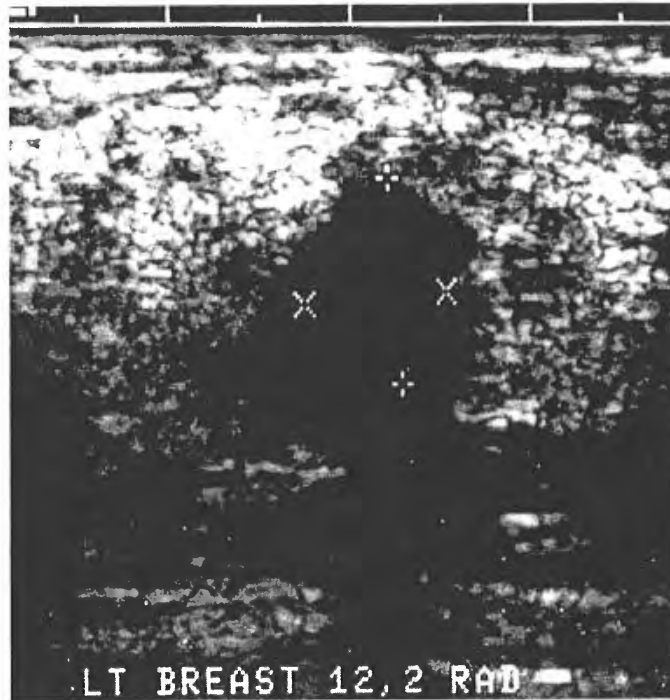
This breast ultrasound demonstrates a hypoechoic, solid mass, which exhibits posterior shadowing and is taller than wide. This BI-RAD 4 lesion proved to be an invasive ductal carcinoma, not otherwise specified (NOS). BI-RAD = Breast Imaging Reporting Data System.
